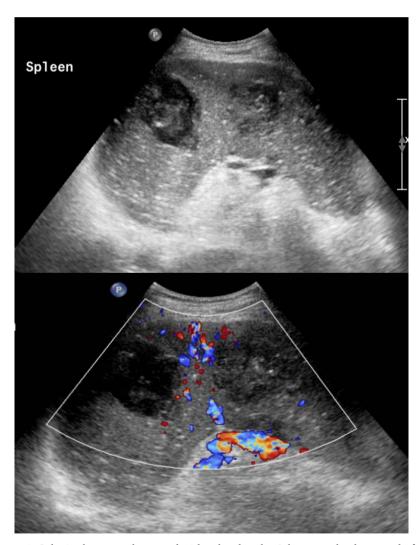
Splenic abscesses ultrasound with color doppler & b gray scale ultrasound of the spleen: 2 Well defined hypoechoic heterogenous lesions with no vascularity in an enlarged spleen with coarse echotexture.
